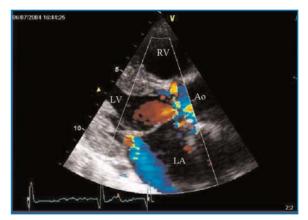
Significant mitral regurgitation in HIV-infected patients with endocarditis, detected by color Doppler trans-thoracic echocardiography (parasternal long-axis view)
